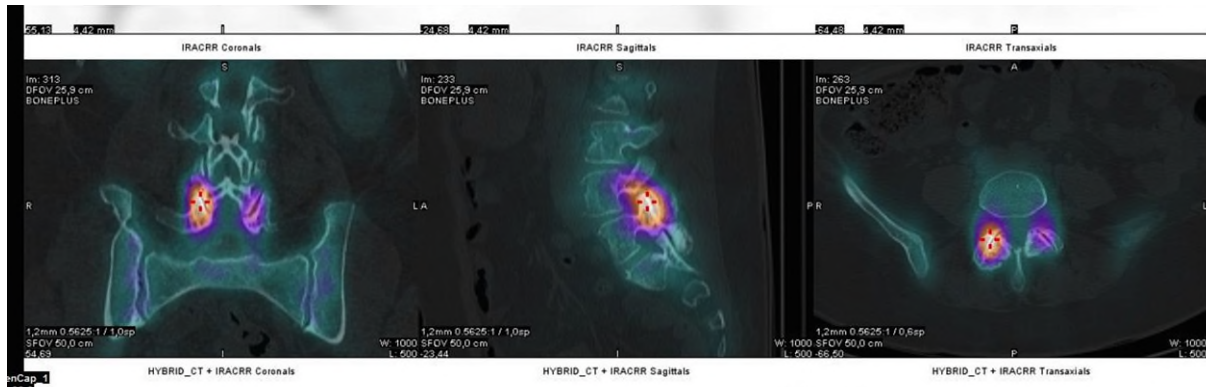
The upper images, the topographic CT-scan images in the three anatomical planes enable, after fusion with the SPECT images (the lower images the exact anatomical localization of the hot spot. This topographic CT image is not used to make a diagnosis on anatomical findings.
